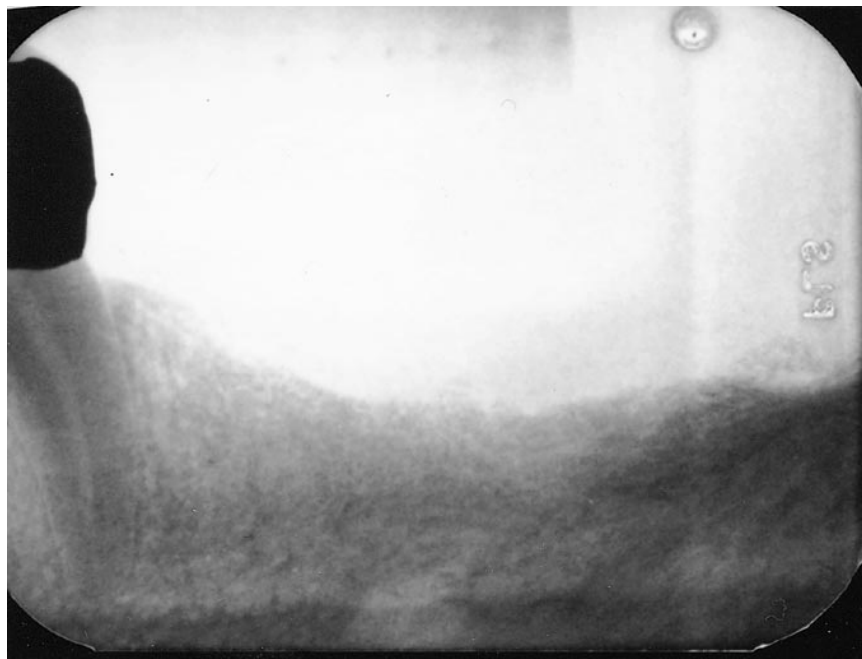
Periapical x-ray taken at right angle.
